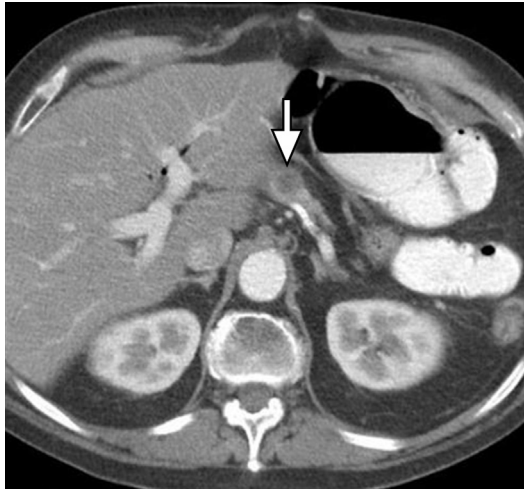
Tumor recurrence after resection. Axial contrast-enhanced multidetector computed tomography (MDCT) image through the pancreatic body after a Whipple procedure and resection of previously diagnosed pancreatic adenocarcinoma in the pancreatic head demonstrate a new focal ill-defined hypodense mass (arrow) in the proximal remaining portion of the pancreas consistent with recurrent tumor.
